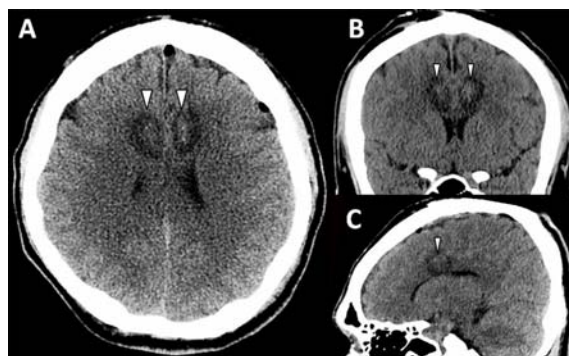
Postoperative CT scan of the brain showing stereotactic lesions (arrowhead) at bilateral anterior cingulate gyrus in axial (A), coronal (B) and sagittal (C) views.
